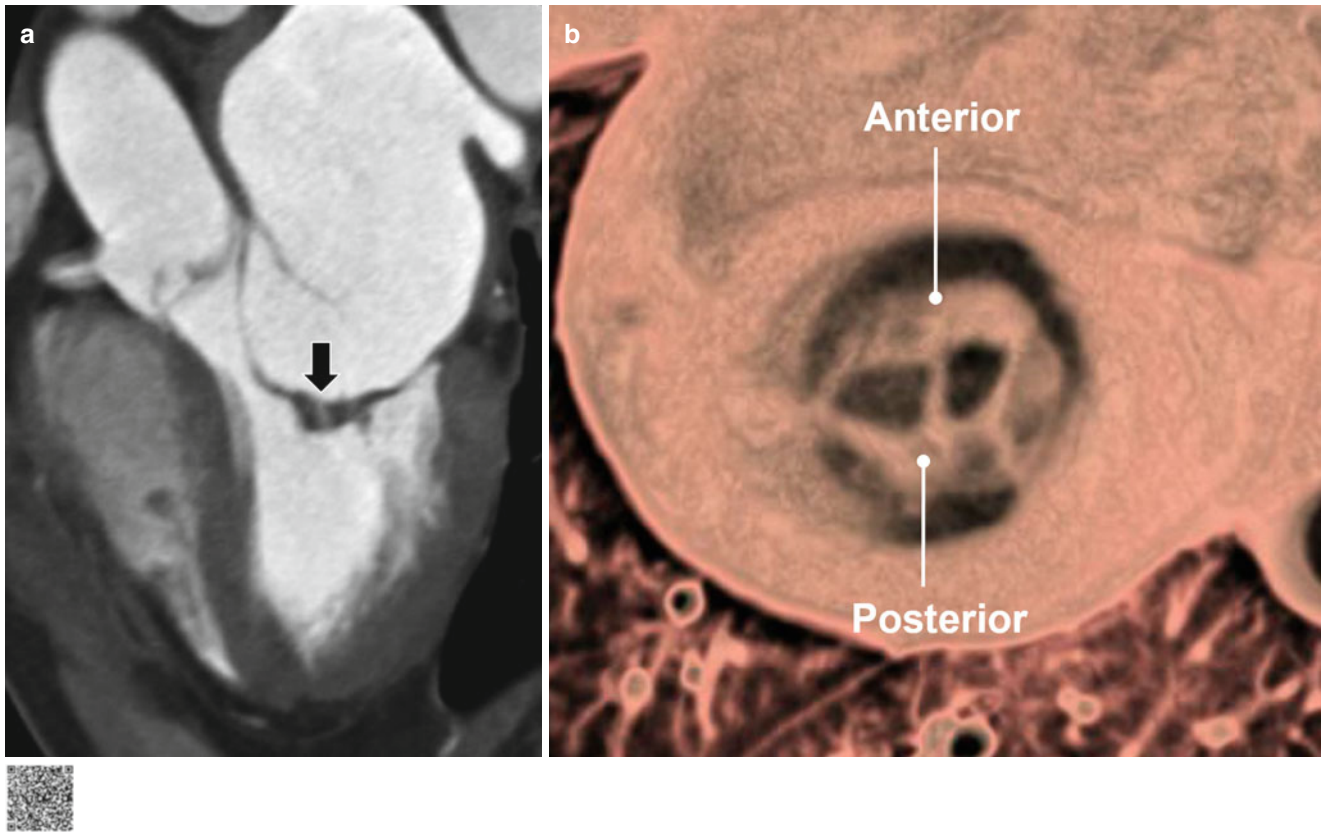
Double orifice of the mitral valve in rheumatic valvular heart disease. (a) Three-chamber view of CT shows a bridging formation (arrow) between the anterior and posterior leaflet of MV. Leaflet tip of MV is thickened due to involvement of rheumatic valvular heart disease.
